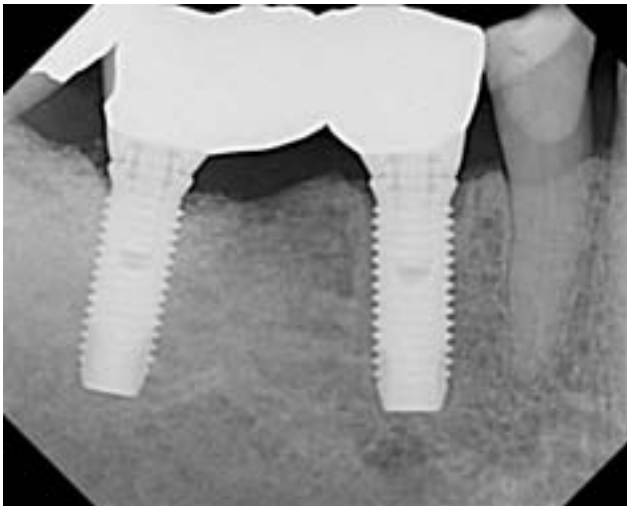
Five-year postrepair radiographic presentation.
